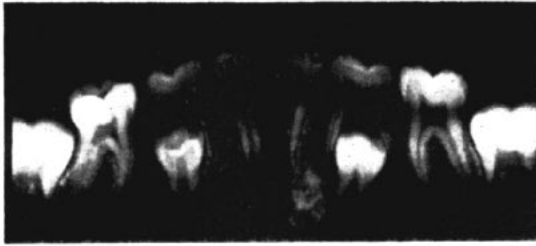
Radiograph of the mandibular second deciduous molar area, showing the position of the erupting bicuspid.
